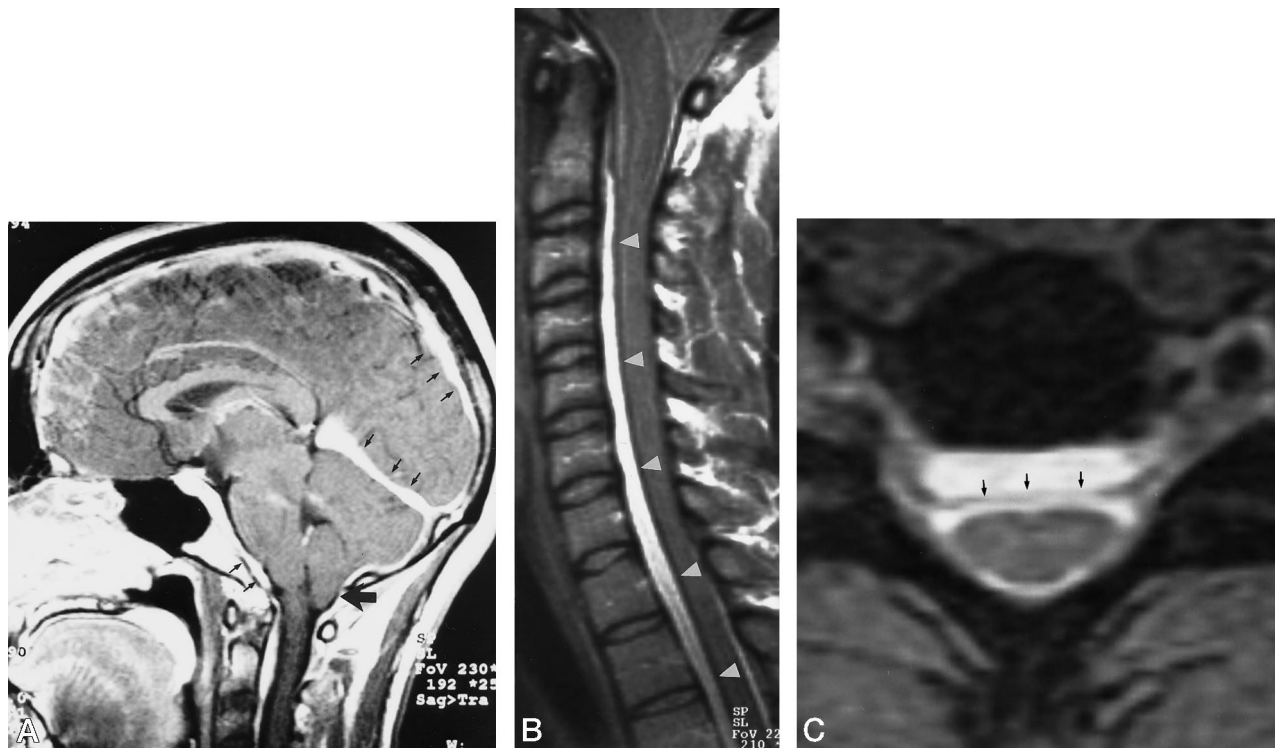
Case 1: 29-year-old woman with severe positional headaches, aggravated by sitting or standing and relieved by lying down. A, Midline sagittal contrast-enhanced T1-weighted (330/15/2) image of the brain shows marked enhancement of thickened pachymeninges (small arrows) and downward displacement of the cerebellar tonsils (large arrow).
